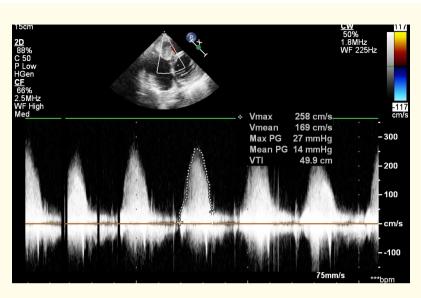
Continuous wave Doppler across tricuspid valve showing a mean diastolic gradient of 14 mmHg.
